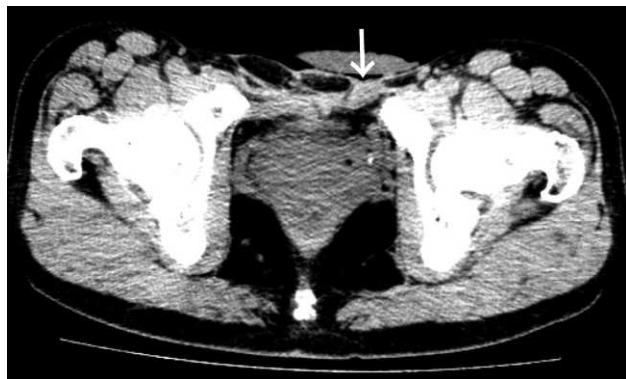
Pelvic CT reveals a cystic subcutaneous mass (white arrow).
